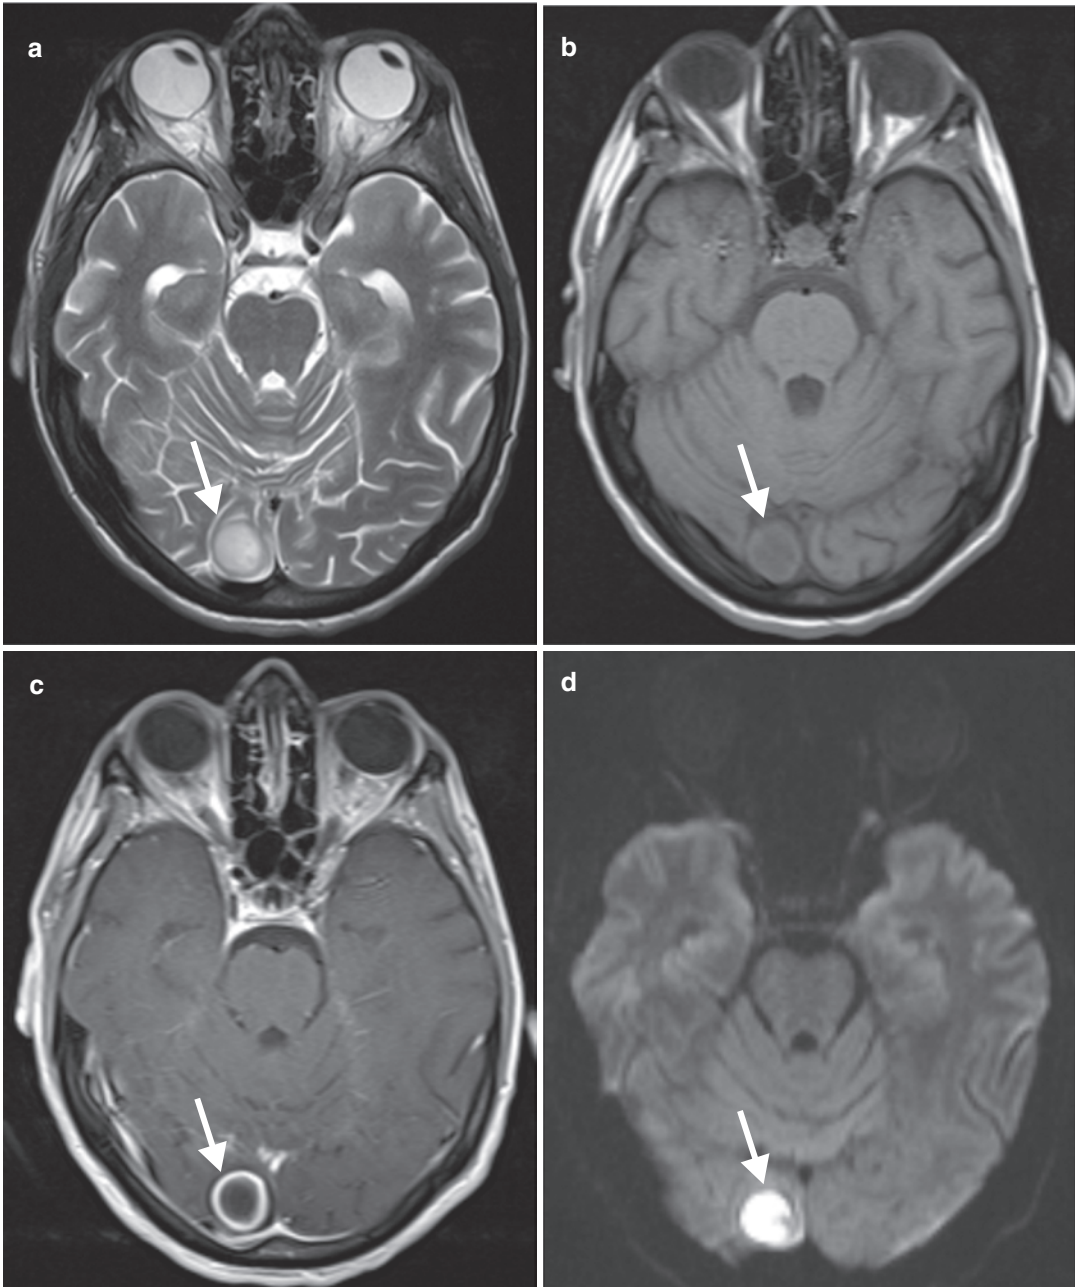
Tuberculous brain abscess. Axial (a) T2-W, (b) T1-W, (c) contrast-enhanced T1-W, and (d) diffusion-weighted MR images show a right occipital mass (arrows)
